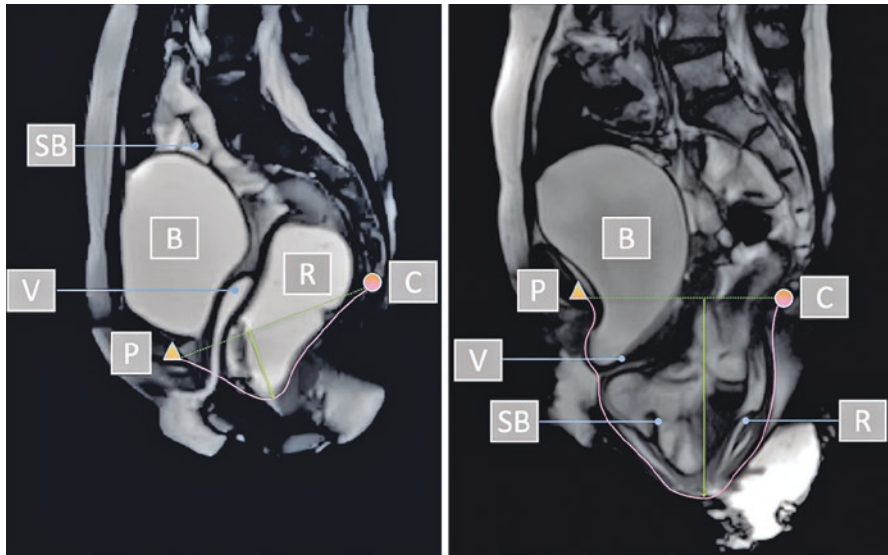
Late stage of perineal descent syndrome with multiorgan and multilevel pelvic prolapse observed with dynamic magnetic resonance imaging, at rest (left) and during bearing down (right). *SB* small bowel, *B* bladder, *V* vagina, *R* rectum, *P* pubis, *C* coccyx
